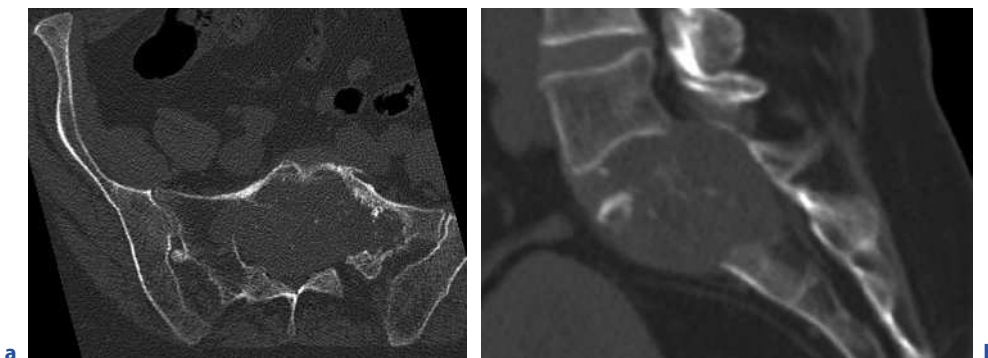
a Axial CT scan demonstrates focal destructive change including destruction of the anterolateral margin of the body with paravertebral and epidural soft tissue extension and b diffuse destructive change of the vertebral body with paravertebral and epidural soft tissue extension
